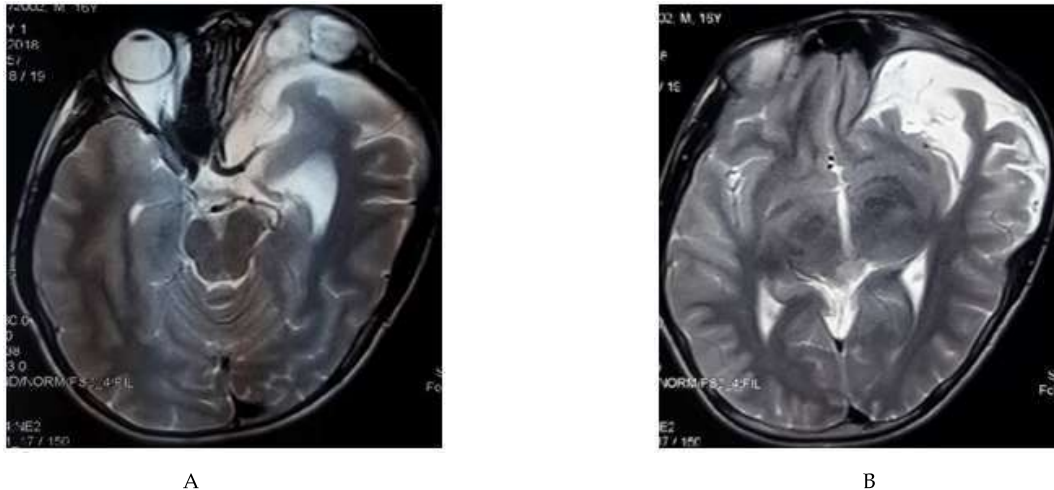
MRI of the brain showing expansion of middle cranial fossa contents with absence of lesser sphenoid wing, causing anterior displacement of the orbital contents (A) ; and presence of dural ectasia (B).
